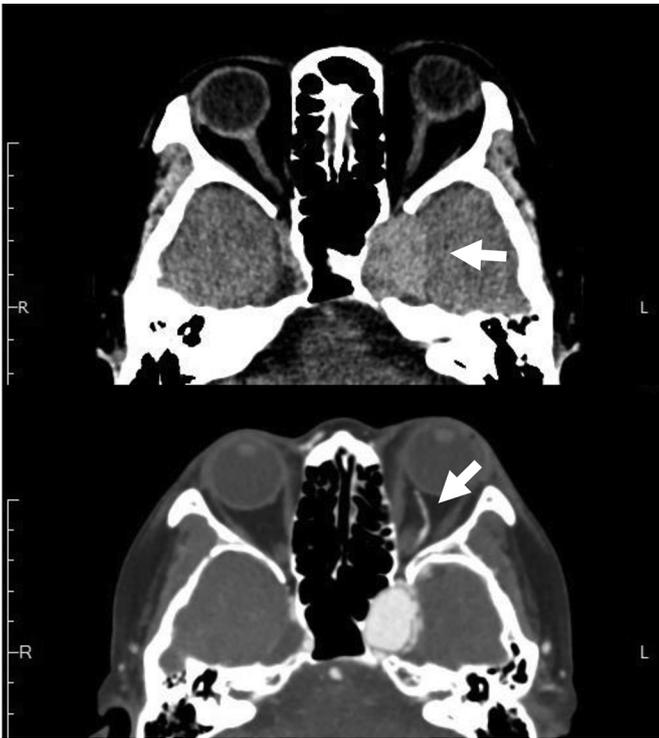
Cranial non-enhanced computed tomography (CT) and CT angiography.
